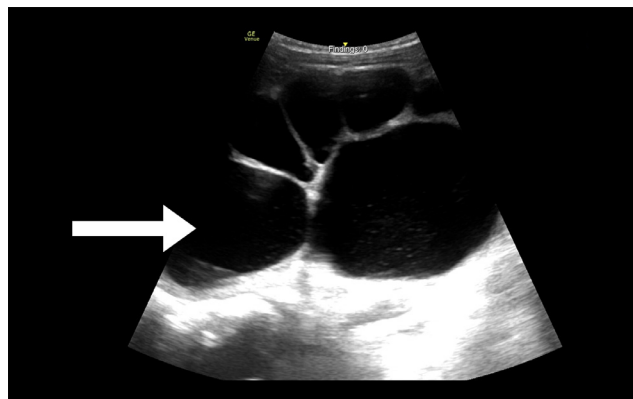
Point-of-care ultrasound of the right kidney demonstrating severe hydronephrosis. Arrow denotes the dilated collecting system as seen in severe hydronephrosis.
